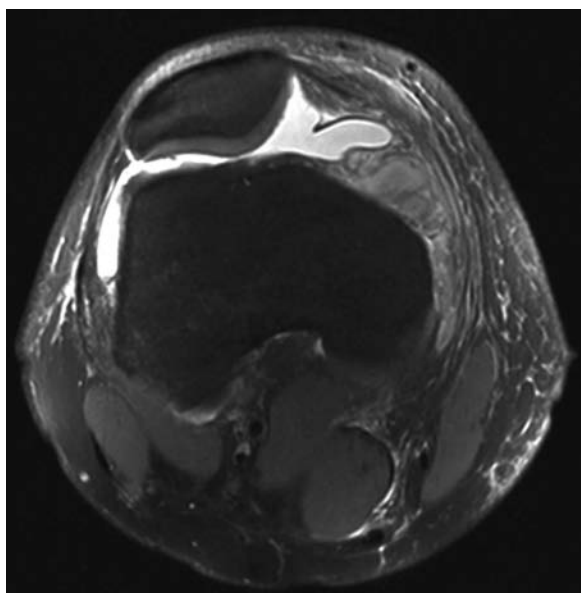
A T2-weighted fat-suppressed magnetic resonance image 2 days after acute patellar dislocation in a 20-year-old man who sustained a traumatic dislocation while playing soccer. Note complete avulsion of the medial patellofemoral ligament at its femoral insertion. A joint effusion is present, and a chondral lesion in the anterolateral femoral condyle is also visible.
